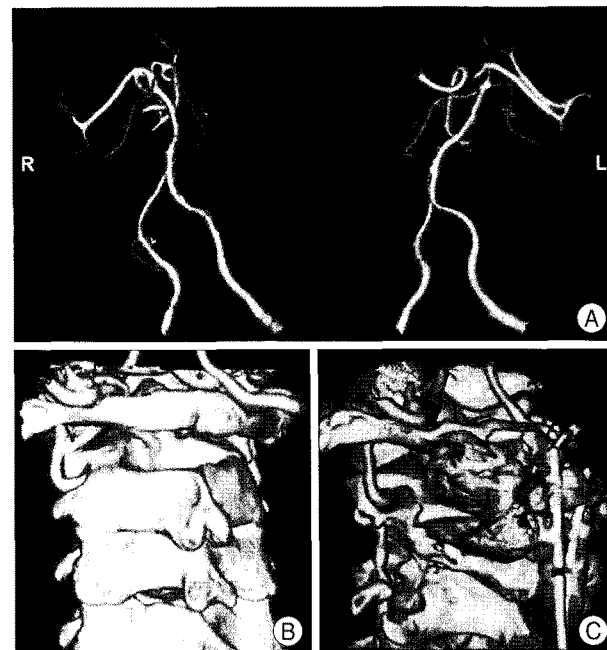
A : Postoperative computed tomographic angiography demonstrating patent flow through the anastomosed vertebral artery. B : Preoperative 3 dimensional reconstruction image of computed tomographic scan of C2 vertebra. C : Postoperative 3 dimensional image of exposed left vertebral artery.
